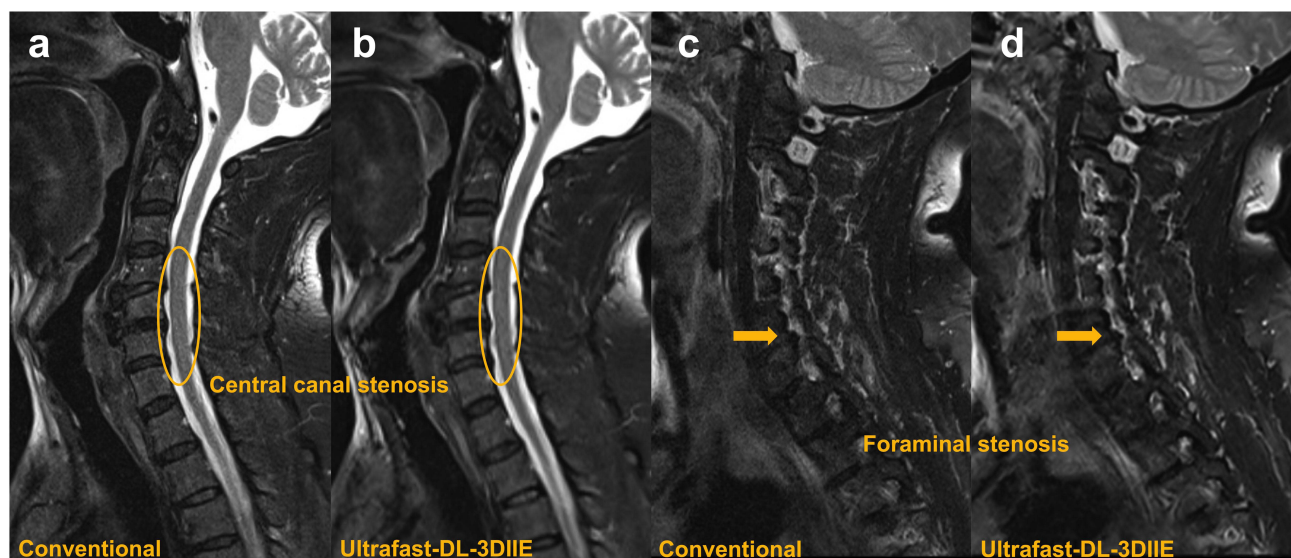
Sagittal T2-weighted images of a participant with central canal stenosis (C3-7 levels, Orange ellipses), were obtained from both conventional (a) and ultrafast-DL-3DIIE (b) protocols. And sagittal T2-weighted images of a participant with foraminal stenosis (C5-6 level, Orange arrows), obtained from both conventional (c) and ultrafast-DL-3DIIE (d) protocols.
